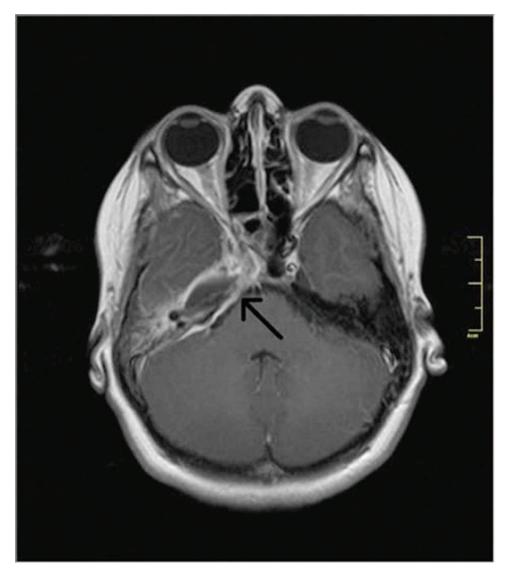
MRI demonstrating oedema in the area of the apex of the petrous bone.
